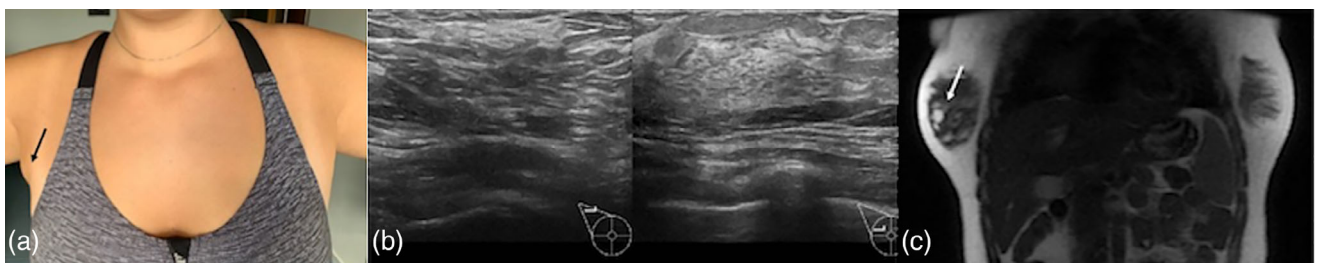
(a) Right accessory breast tissue (arrow) in a 17-year-old girl. (b) Ultrasound scan showing that the tissue in the axillary swelling (left panel) is similar to breast tissue (right panel). (c) Coronal magnetic resonance imaging showing bilateral accessory breast tissue, however, it was more pronounced on the right (arrow).
